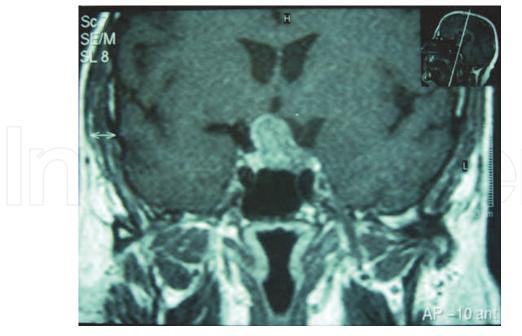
a. Coronal T1W MRI sequence of the brain with gadolinium showing a large pituitary macroadenoma displacing the optic chiasm superiorly and the pituitary gland to the right side. The patient suffered visual field disturbances.
